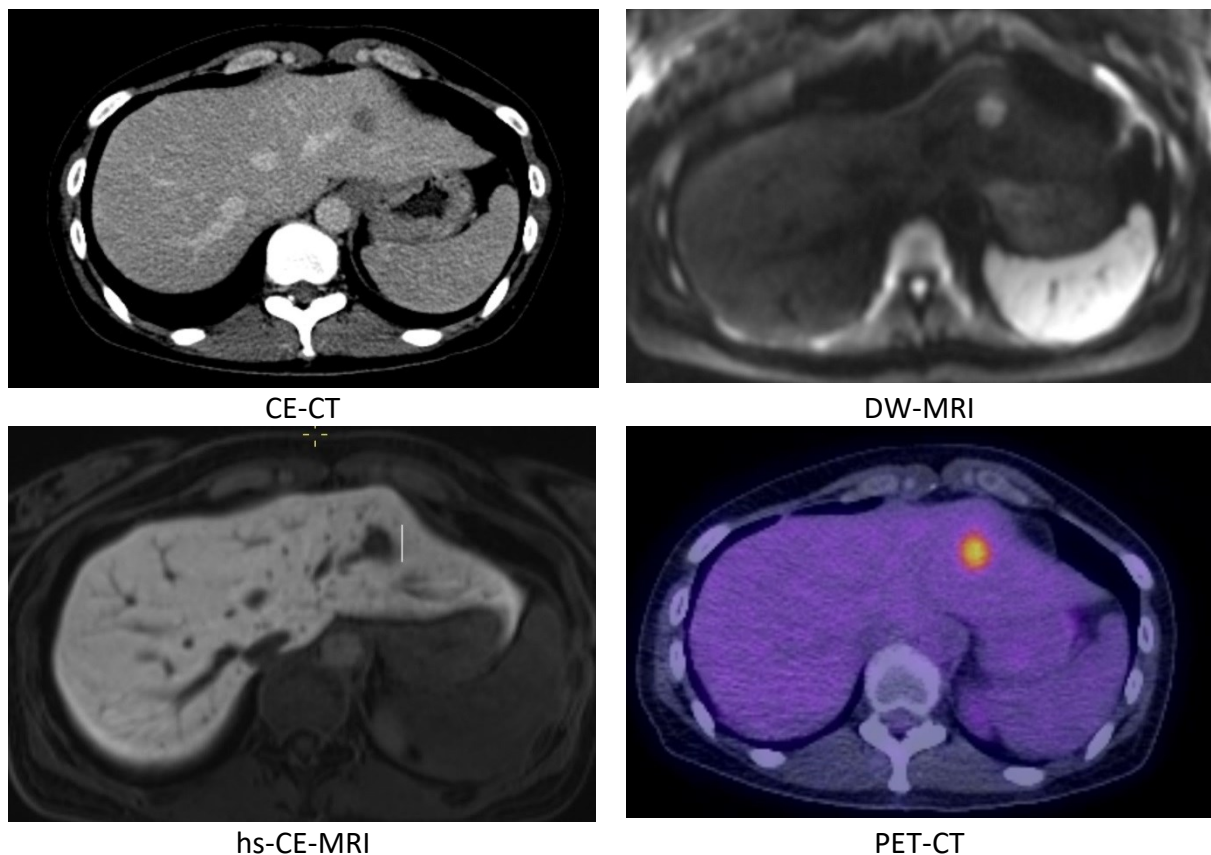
Example of a patient with a solitary liver metastasis in segment II and its appearance on CT, DW-MRI, hs-CE-MRI and PET-CT.
